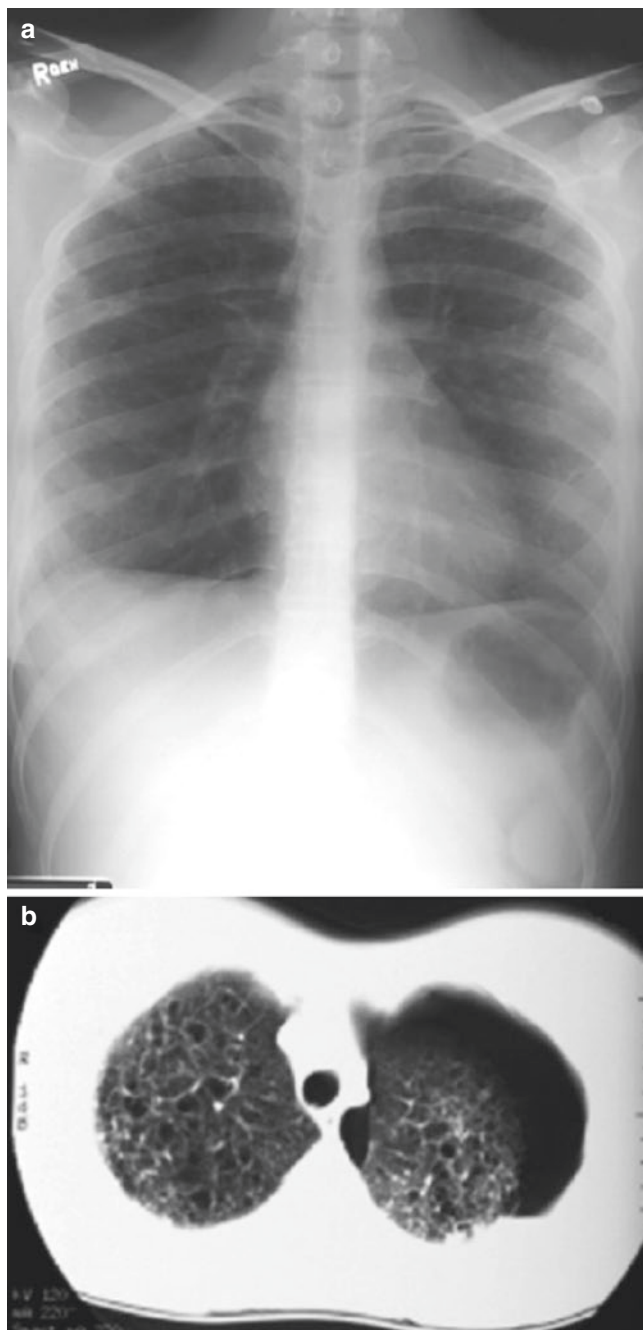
Localized form of Langerhans cell histiocytosis in an 18-year-old male smoker. (a) Frontal radiograph shows upper lobe-predominant interstitial lung disease. (b) Axial non-enhanced lung window CT image shows diffuse small lucent cysts throughout the upper lobes and a left spontaneous pneumothorax
